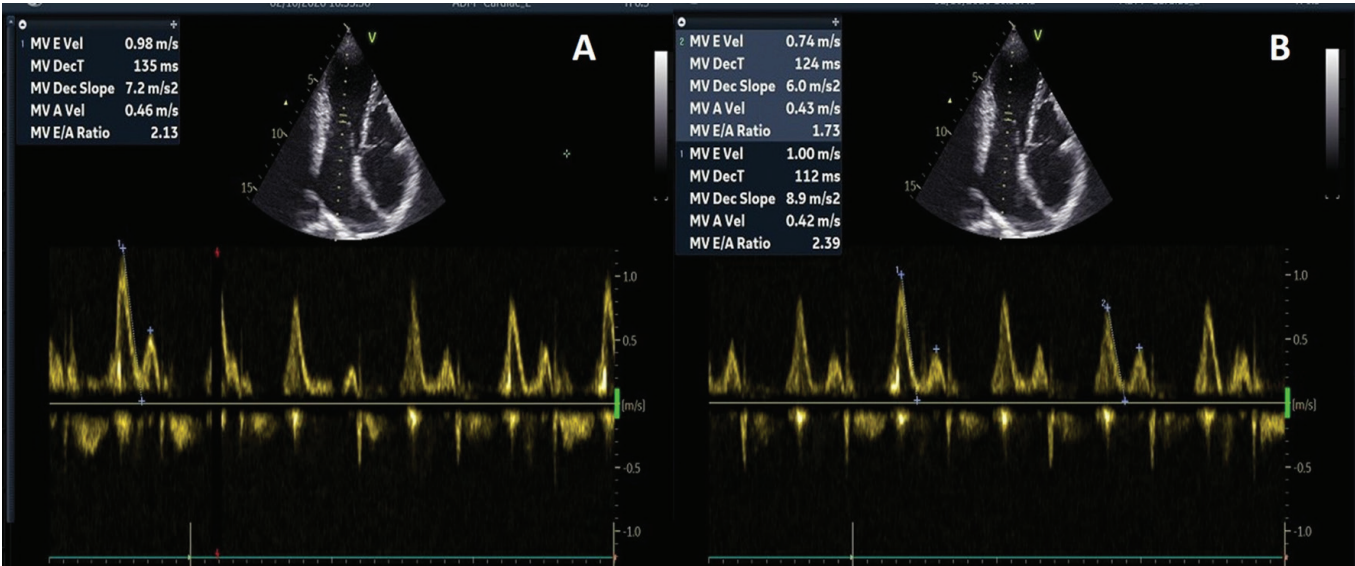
(A) E/A ratio was 2.13 on mitral inflow Doppler. (B) Respiratory variability was observed in mitral (>25%) inflow on Doppler echocardiography
